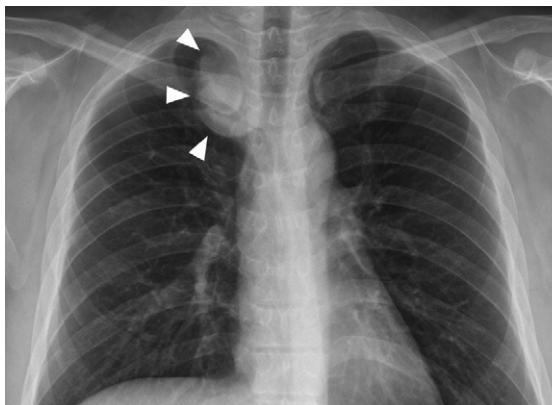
Plain chest roentgenography shows an expansile upper paratracheal mass (arrowheads).
